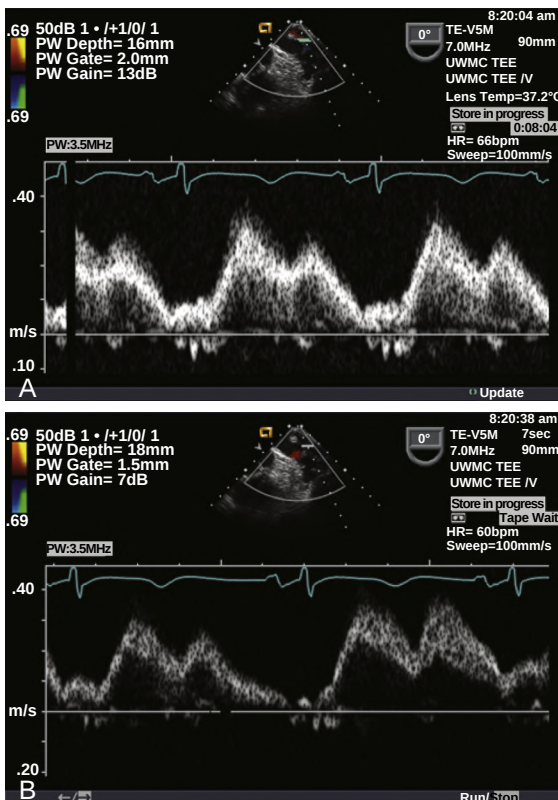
Pulsed Doppler gain setting. The effect of Doppler gain settings are shown for a TEE recording of pulmonary vein inflow. Excess noise is eliminated; then the gain is decreased from 13 dB (A) to 7 dB (B).
